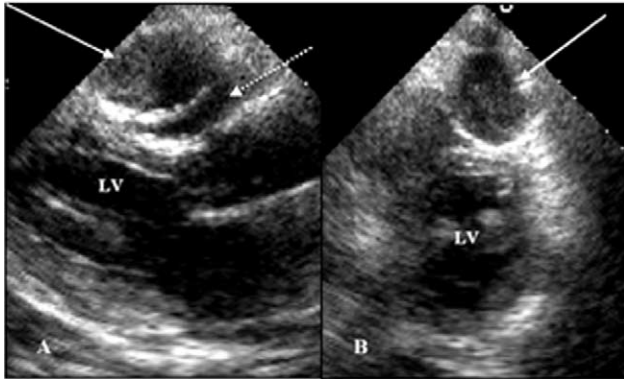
(A) Echocardiogram showing extrinsic compression of right ventricle (dashed arrow) by mass (solid arrow) on parasternal long axis view. (B) The arrow points to mass abutting the right ventricle and anterior wall of the left ventricle on short-axis view. (LV = left ventricle.)
